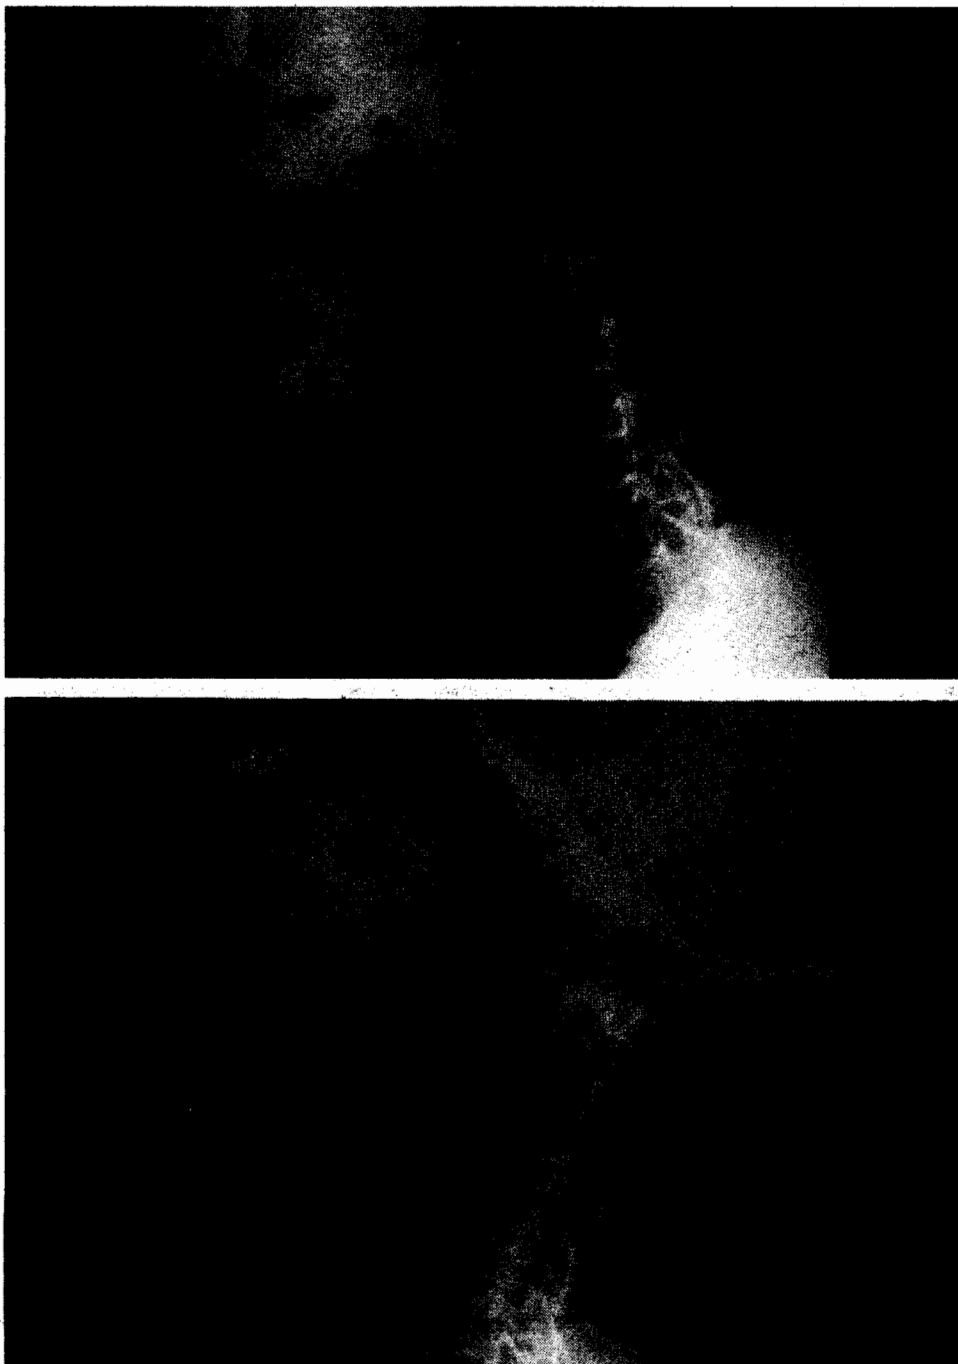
Flexion-extension lateral radiographs made 4 months after injury, show kyphotic deformity and subluxation of C1 on C2. (Old fracture dens).
